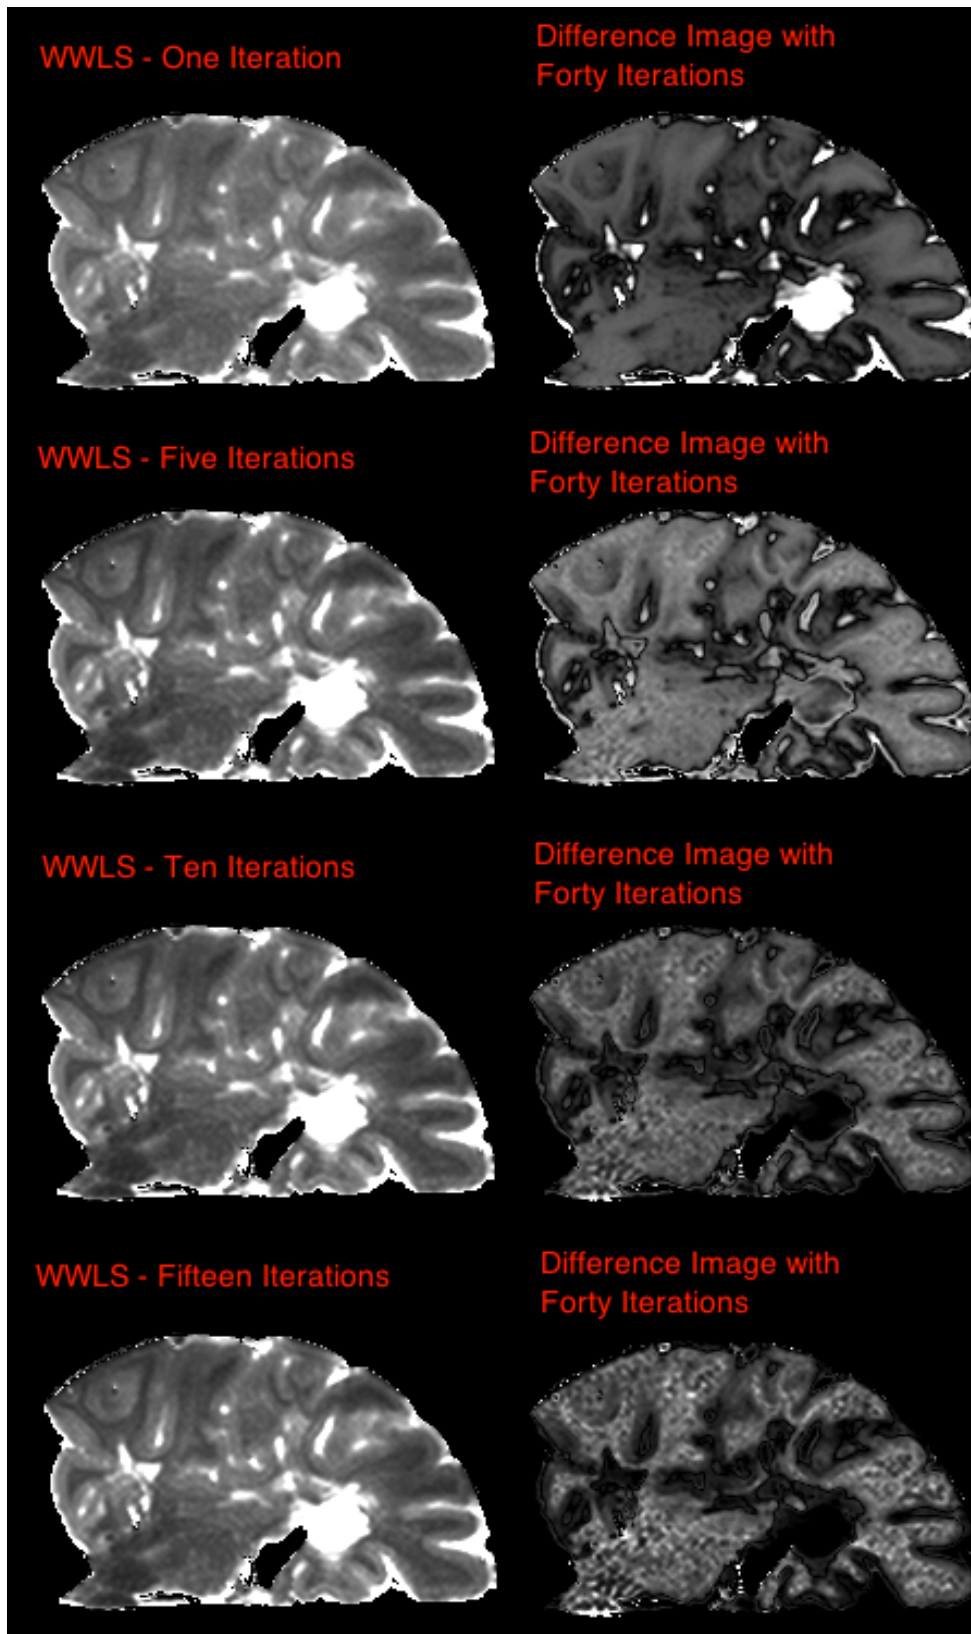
DIFFERENCE IMAGES FOR 1, 5, 10 AND 15 ITERATIONS WITH 40 ITERATIONS, PRODUCED USING THE WLLS ALGORITHM. ALL T1 MAPS ARE SCALED BETWEEN 0 AND 1000MS, AND 1, 5, 10, AND 15 ITERATIONS DIFFERENCE IMAGES BETWEEN 0 TO 200, 0 TO 10, 0 TO 0.5 AND 0 TO 0.02MS RESPECTIVELY
